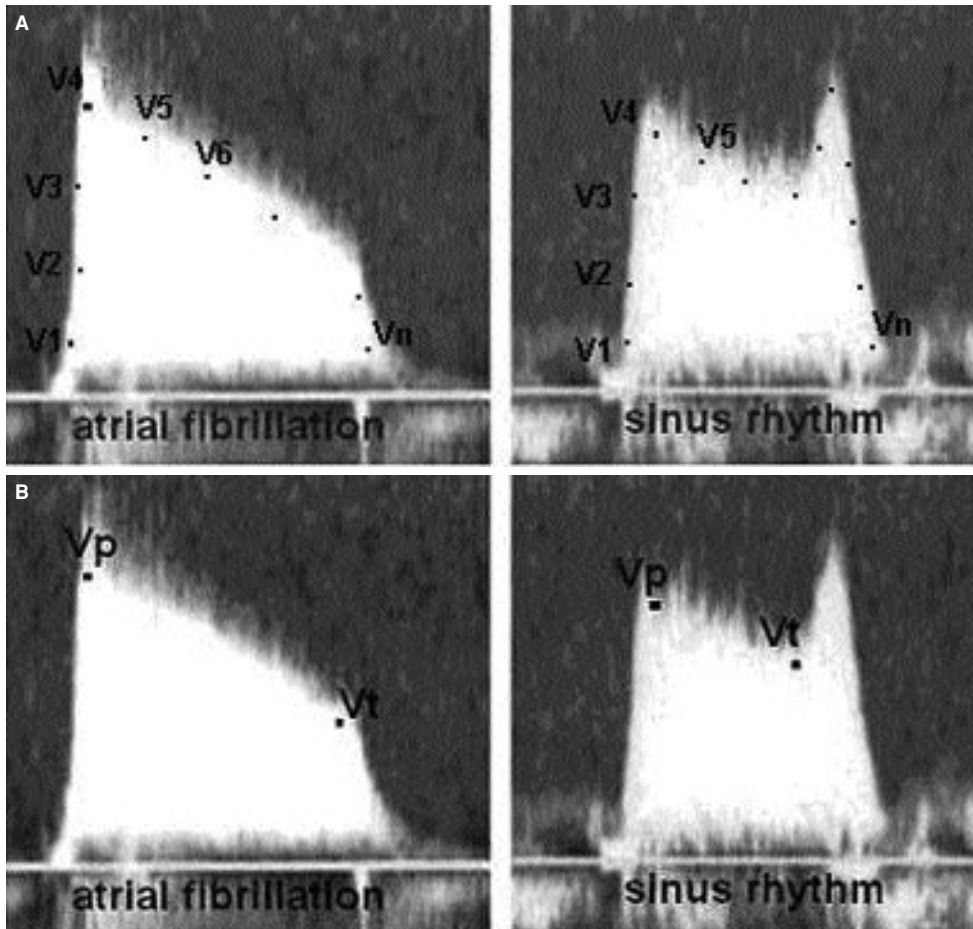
(A) Tracing of the Doppler signal in the standard method. (B) Determination of only peak (V_p) and trough (V_t) velocities in the new methods.
